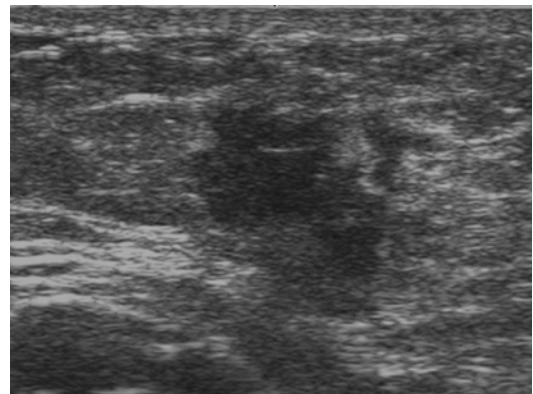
Breast carcinoma explored by ultrasound scan
